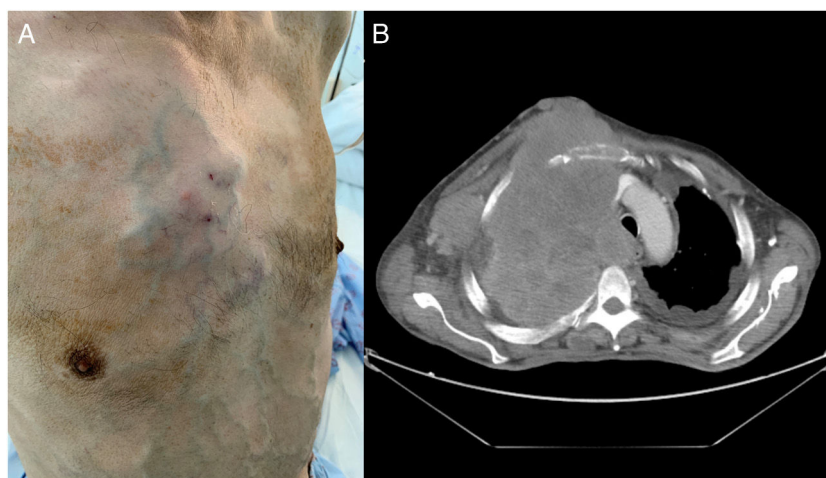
(A) Frontolateral view of the chest with tumor caused by lung mass, showing secondary collateral circulation. (B) Thoracic CT slice with extensive infiltrating mass.
